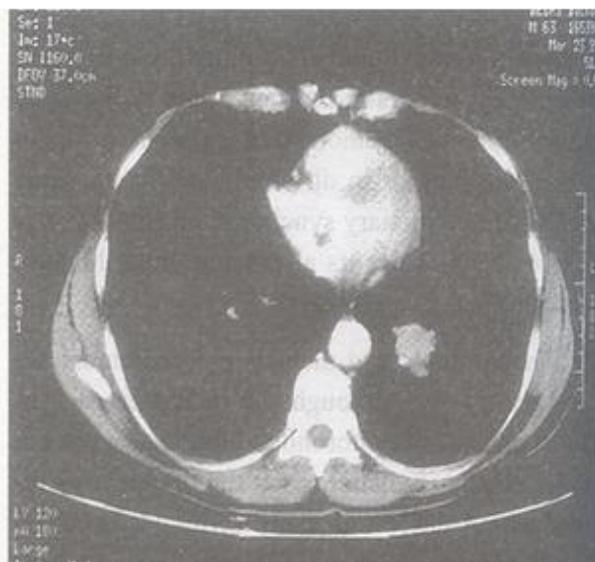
CT of the lower lobe tumor.
